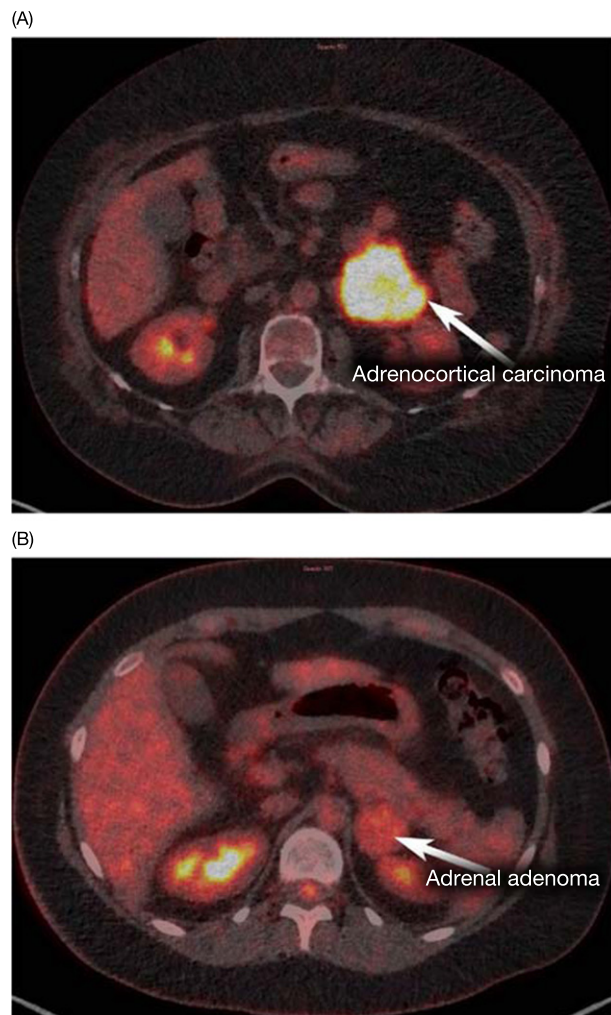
^{18}F -FDG PET/CT scan of an adrenocortical carcinoma (A) and adrenocortical adenoma (B). Arrow showing tumor with a high SUVmax in the left adrenal gland in (A) consistent with an adrenocortical carcinoma and arrow showing low SUVmax in the left adrenal mass in (B) consistent with an adrenocortical adenoma.
